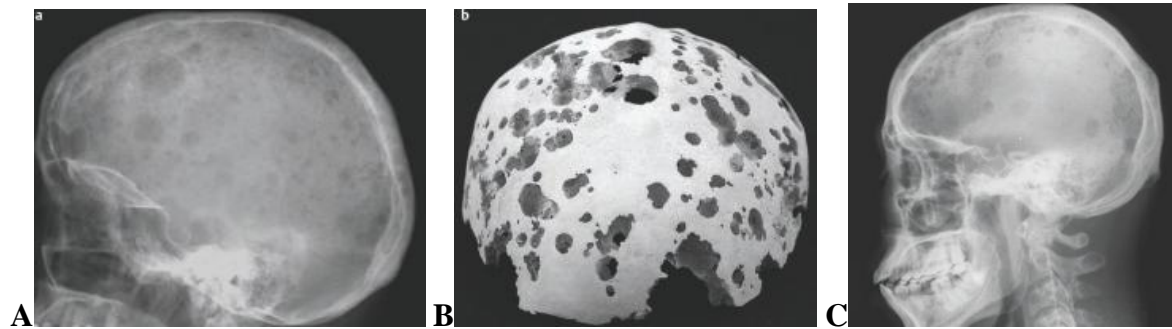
(A) A lateral head radiograph demonstrates innumerable variably sized lytic lesions throughout the skull. (B) 3-D CT-reconstruction of skull. This appearance is typical for advanced multiple myeloma, which was this patient's diagnosis. (C) A lateral head radiograph of different patient, multiple myeloma of skull.
